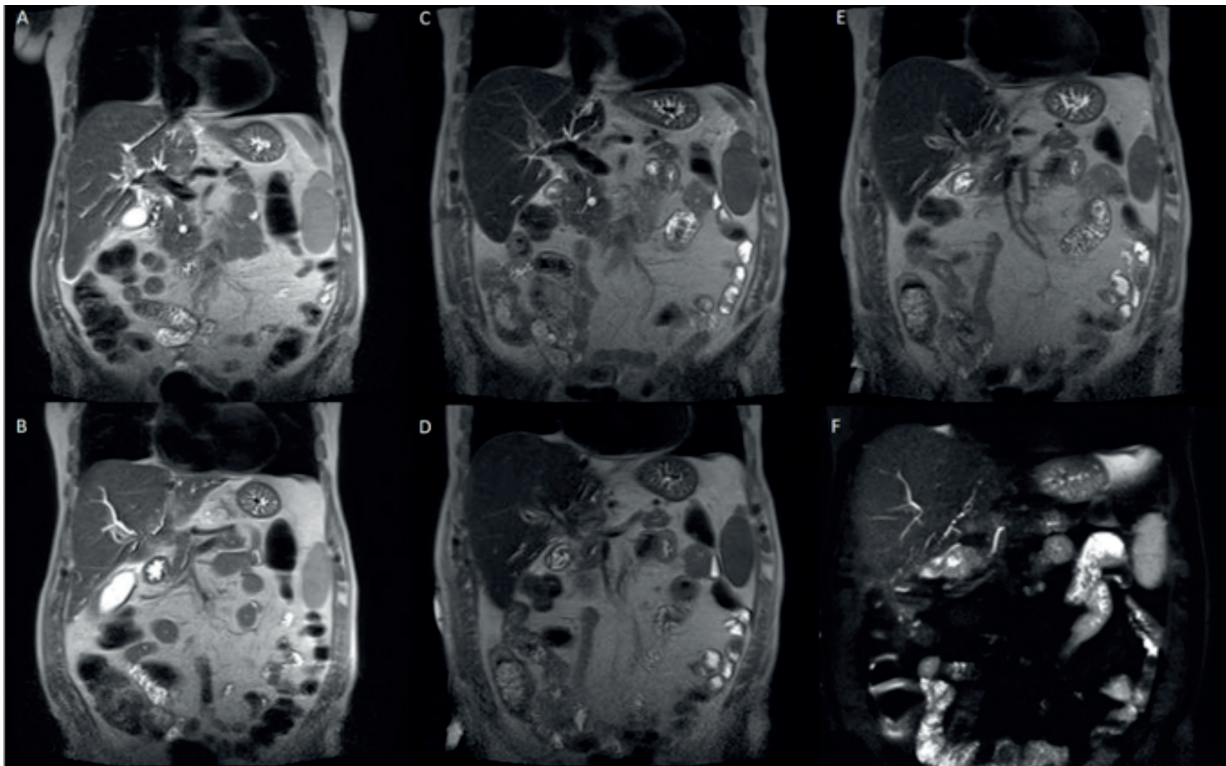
T2 weighted MR images in coronal plane before (A-B), after 2 months (C-D) and after 4 months from ECT (E-F).
